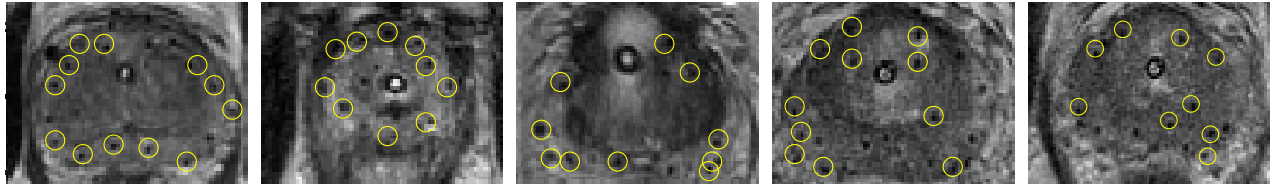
Registered seeds overlaid on MR images of the prostate. The presented registered seeds are only one pixel long. Therefore, some seed-like voids in each slice may be associated with registered seeds in an adjacent slice that are not shown.
